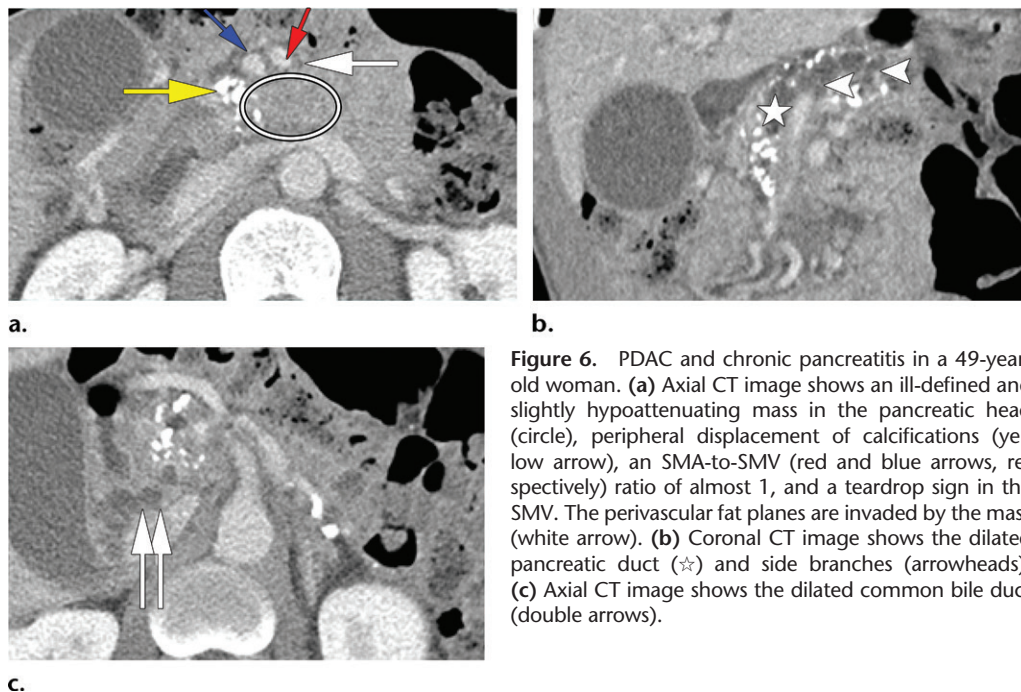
PDAC and chronic pancreatitis in a 49-year-old woman. (a) Axial CT image shows an ill-defined and slightly hypoattenuating mass in the pancreatic head (circle), peripheral displacement of calcifications (yellow arrow), an SMA-to-SMV (red and blue arrows, respectively) ratio of almost 1, and a teardrop sign in the SMV. The perivascular fat planes are invaded by the mass (white arrow). (b) Coronal CT image shows the dilated pancreatic duct (☆) and side branches (arrowheads). (c) Axial CT image shows the dilated common bile duct (double arrows).
